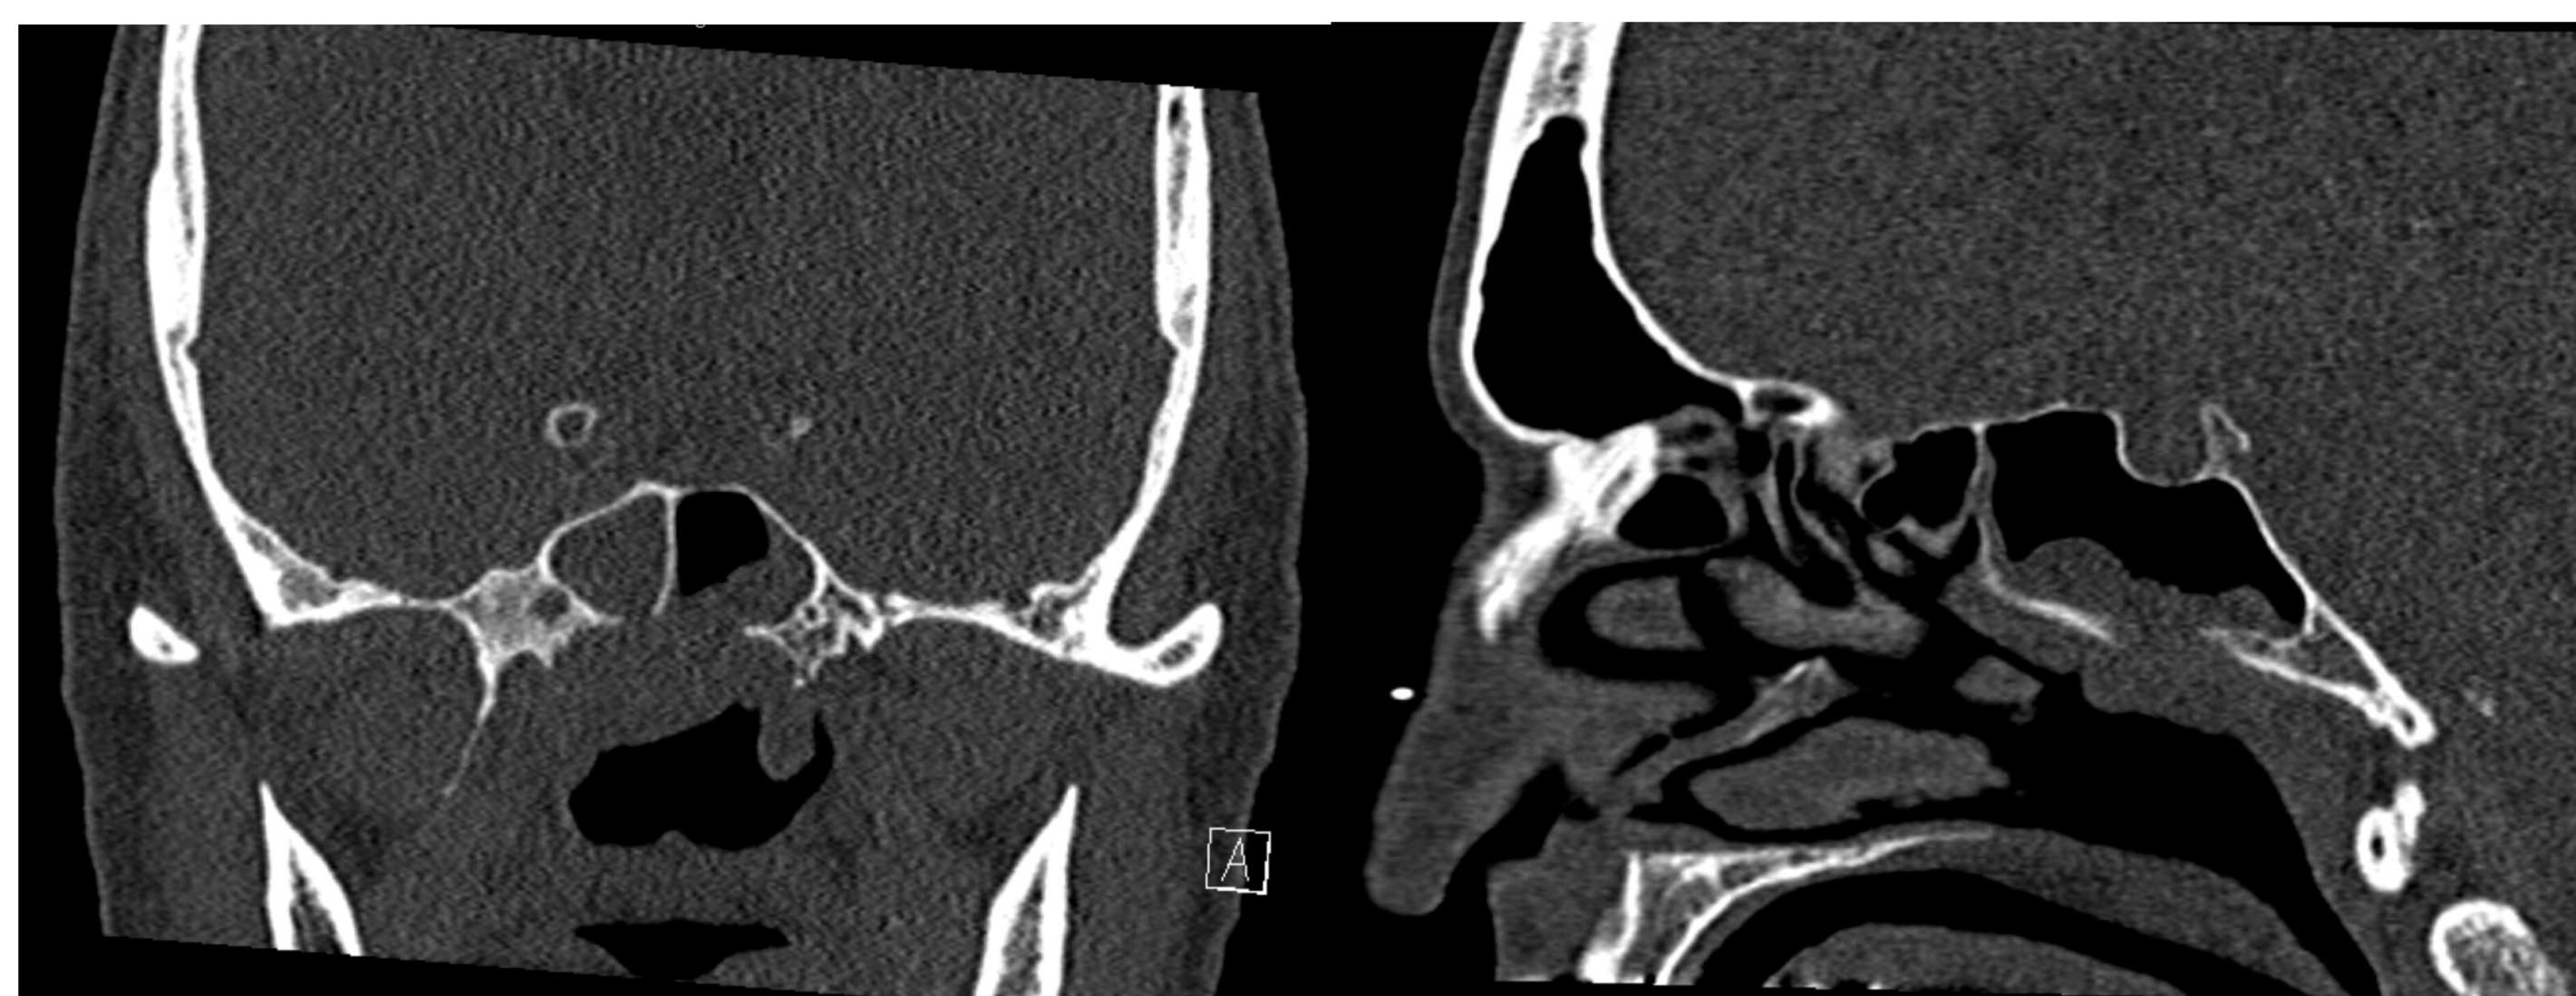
Preoperative CT demonstrating a nasopharyngeal and sphenoid sinus mass with erosion of the floor of the sphenoid sinus.
